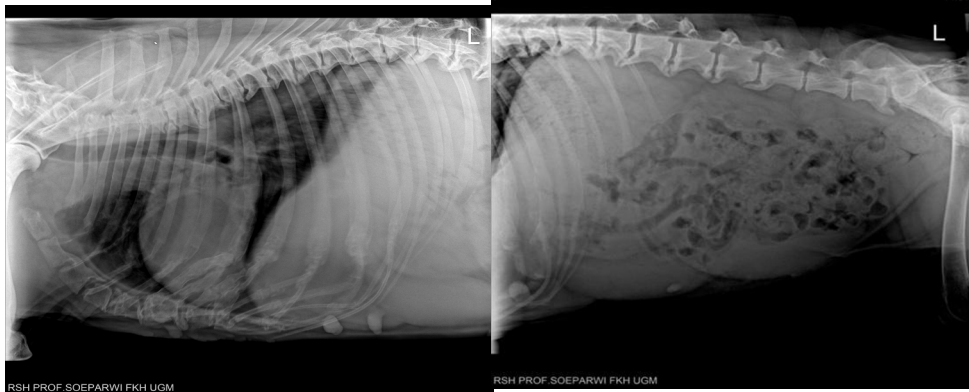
Thoracic radiographs were obtained in left lateral projection. The cardiac and pulmonary silhouettes appeared within normal limits, and no nodular or interstitial patterns suggestive of metastatic lesions were observed (A); Abdominal radiographs revealed a marked enlargement of the spleen extending into the ventral abdomen (B).
